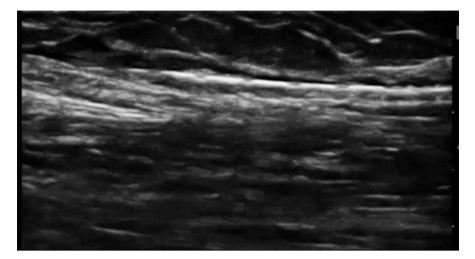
Ultrasound imaging showing electrode over ulnar nerve
